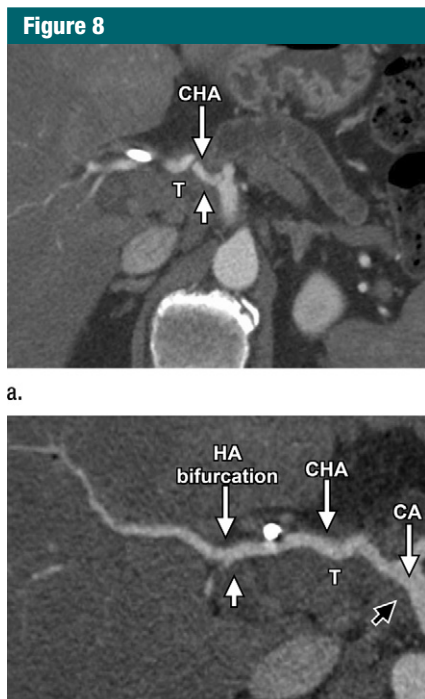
Images in a 70-year-old man with tumor in contact with the CHA. (a) Axial contrast-enhanced biphasic multidetector CT angiogram demonstrates a mass in the pancreatic head mass (*T*) in contact with the CHA (short arrow). (b) The length of contact is better delineated on the curved planar reformatted image through the length of the vessel, which shows that the tumor contact extends to the hepatic artery bifurcation (short white arrow) and the celiac axis (short black arrow). The extension to the celiac axis places the patient in the unresectable category. HA = hepatic artery.
